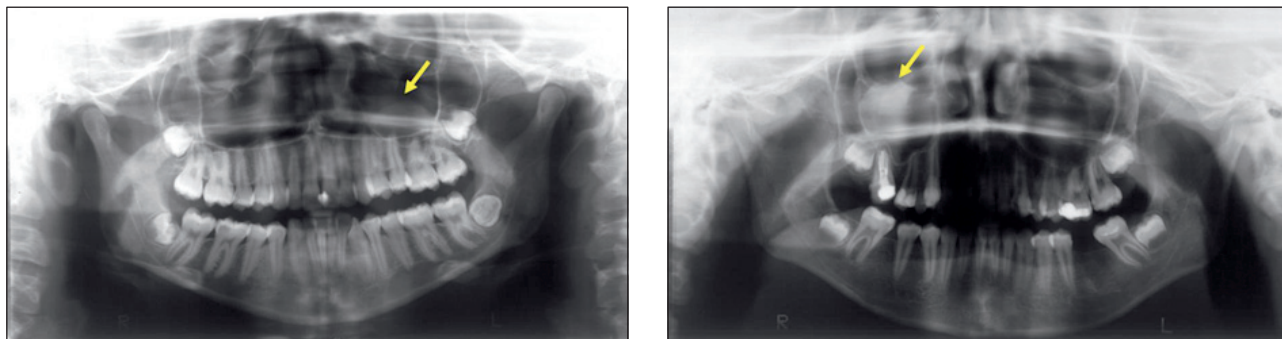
Panoramic radiographs showing maxillary sinus opacification corresponding to antral pseudocyst.
